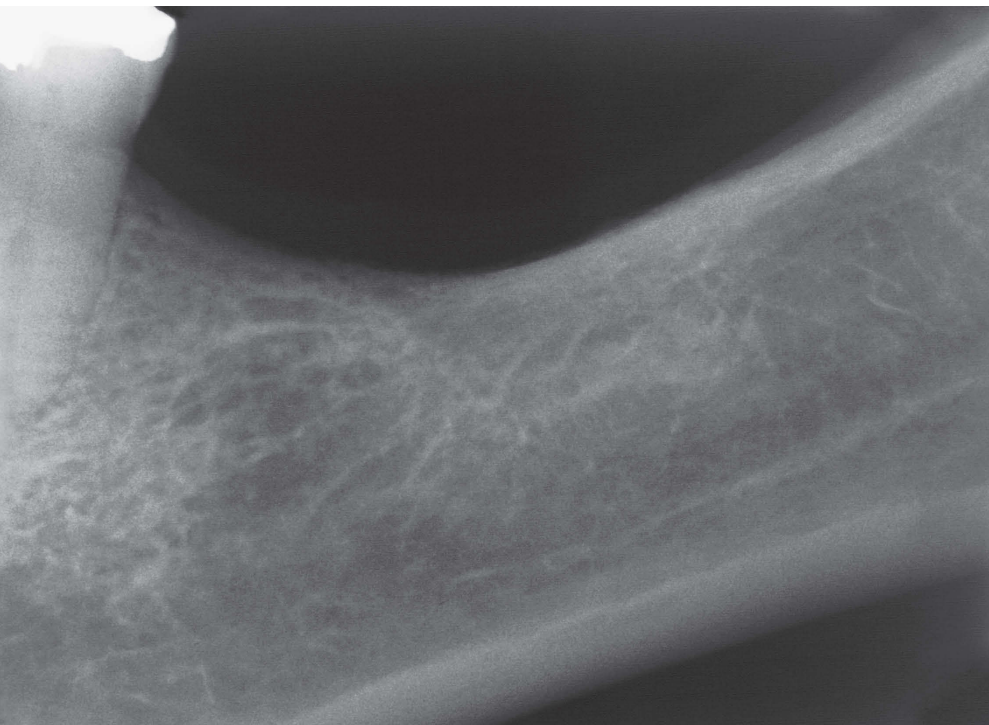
Bone structure density in bone repair after extraction may vary significantly according to previous conditions such as periodontal disease, periapical periodontitis, fracture, etc.
